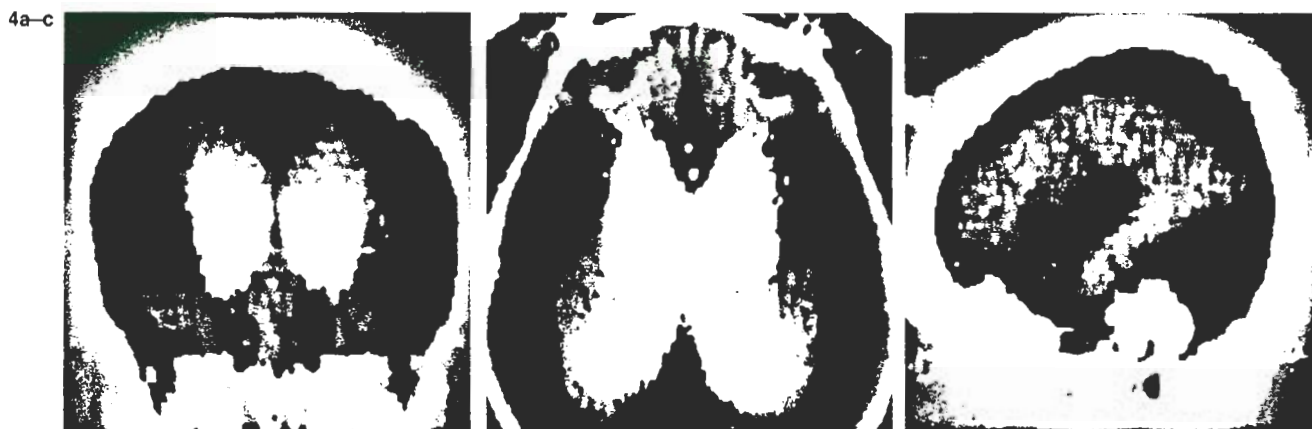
3D noncontrast CT scans demonstrate dual skin-CSF surfaces in a 22-month-old boy with mild hydrocephalus. a: Anterior view. b: Superior view. c: Lateral view. Portions of the skin have been shaved away to provide windows for viewing the ventricles. Simultaneous display of the skin surface and the ventricles provides valuable landmarks for selecting the entry point for placing shunt catheters.
